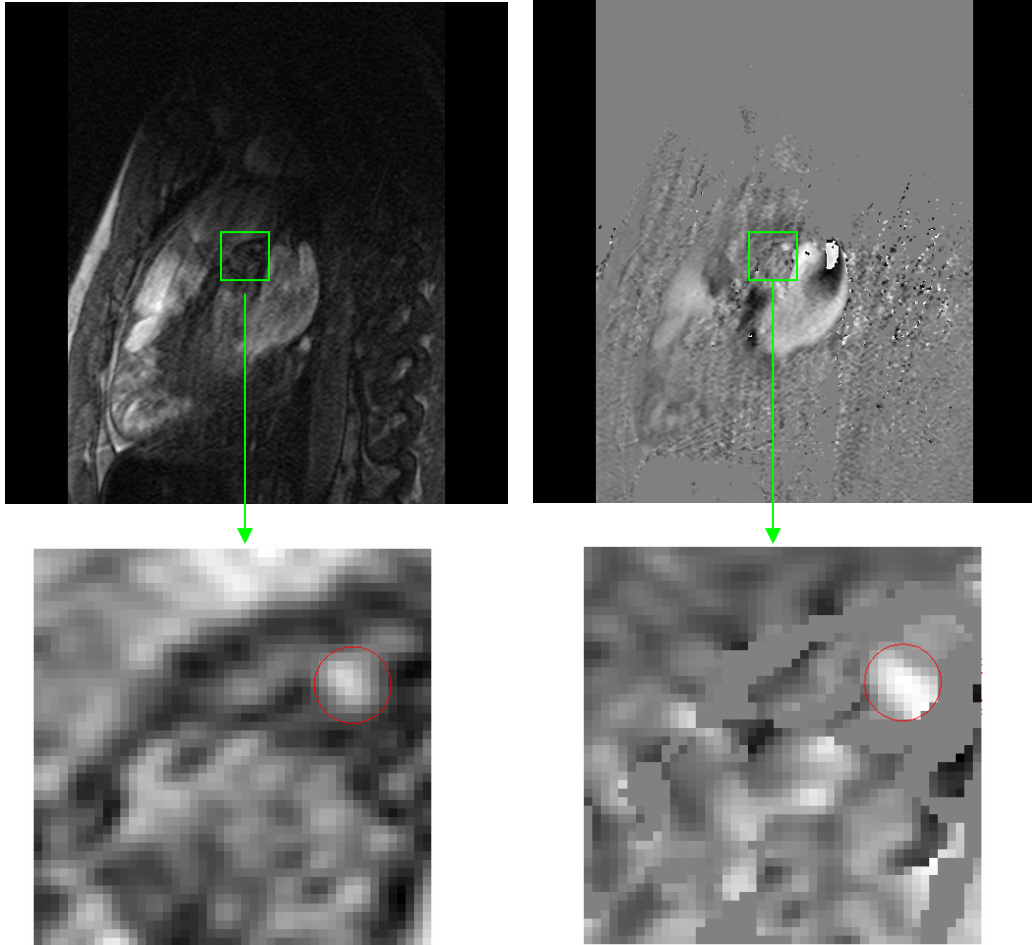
PC-MRI slices of the left coronary artery in diastole; the left panels are the modulus images and the right panels are the phase images; the lower figures are the zoom-in images
